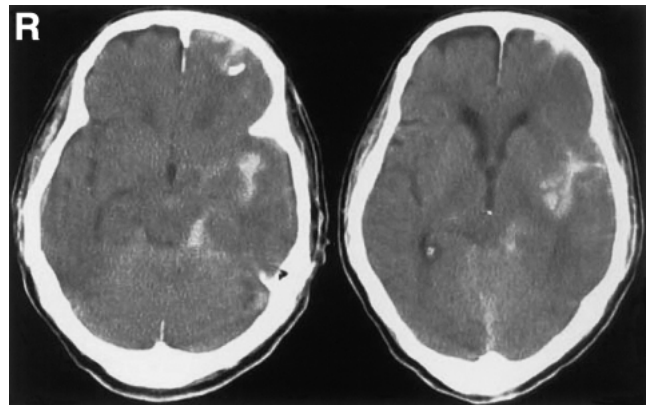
Second computed tomography scans immediately after thrombolysis showing hemorrhagic infarction in the territory of the recanalized middle cerebral artery and intracerebral hemorrhage in the frontal lobe.
